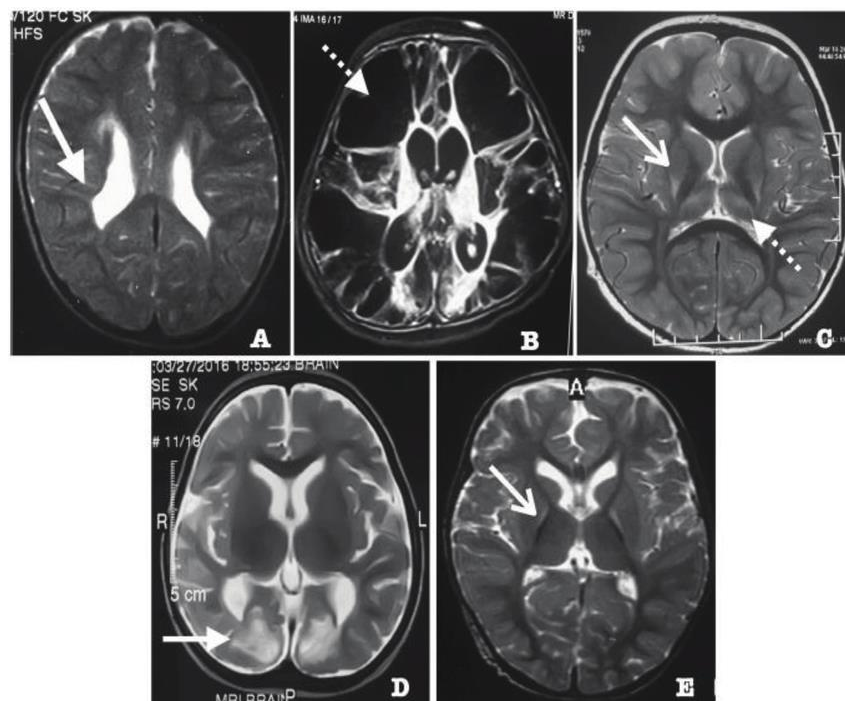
MRI changes in cerebral palsy shows a T2-weighted image with periventricular hyperintensities and undulating ventricular margins<sup>19</sup>
